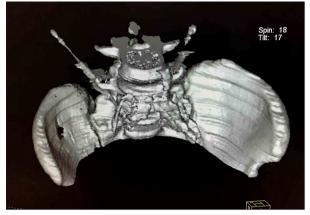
Three-dimensional reconstruction after computed tomography indicating that the dehydrated alcohol solution is distributed along the anterior margin of the L5 and S1 vertebral bodies and the anteromedial margin of the psoas major muscle.
